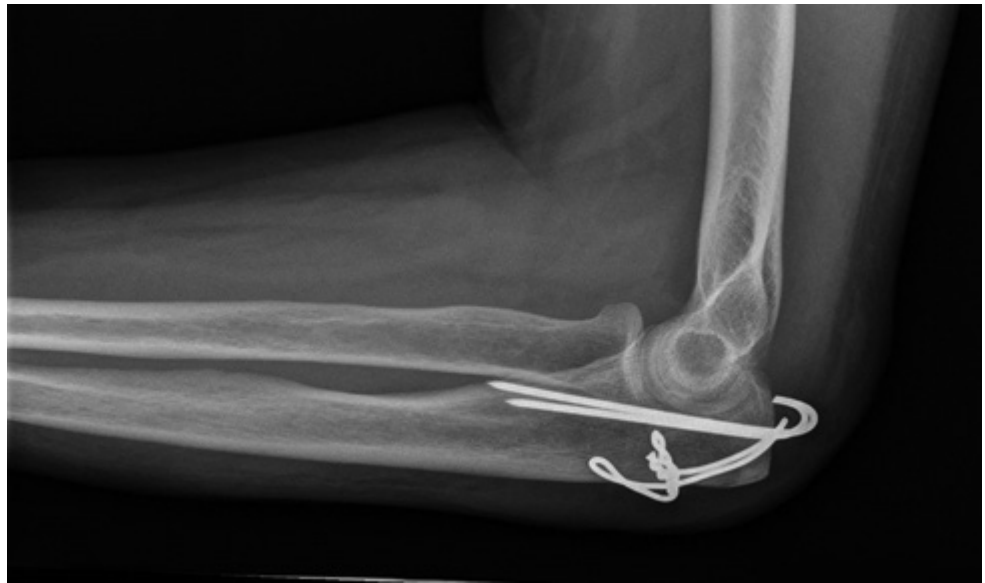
Lateral plain X-ray of tension band fixation of the olecranon.
